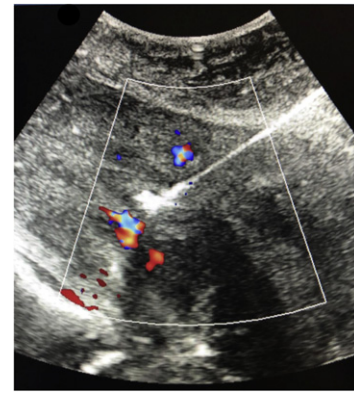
RF ablation zone of a placental vascular bundle (Doppler Imaging) under ultrasonography with hyperechoic image of the needle electrode and gas bubble formation at its tip.
